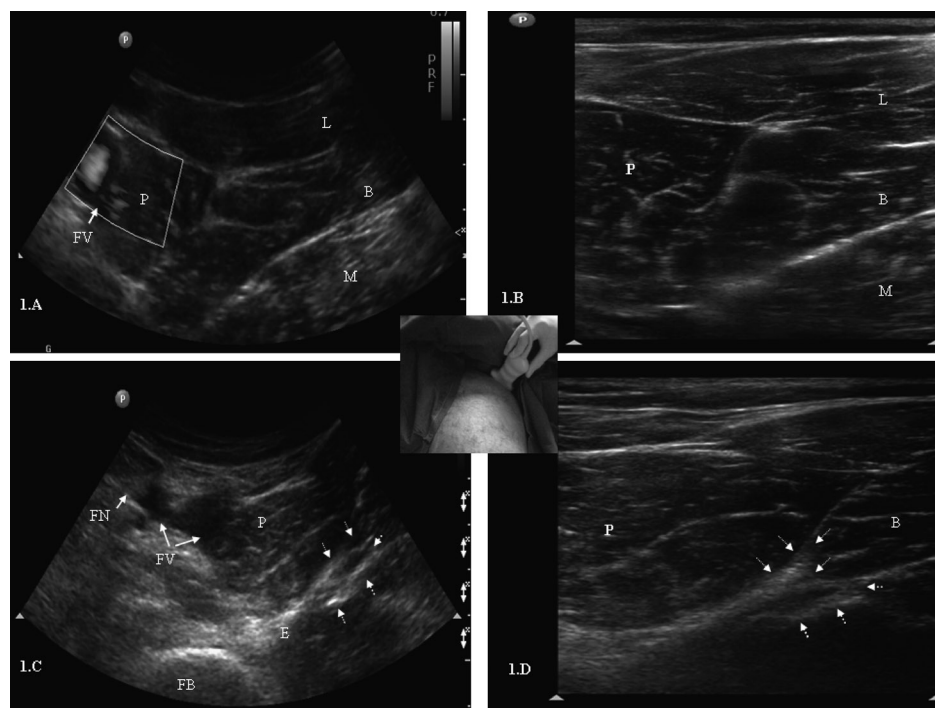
Ultrasound identification of the obturator nerve. (A) The curved 2 to 5 MHz and (B) the linear 5 to 10 MHz transducers were placed perpendicularly just below the inguinal ligament, at the pubic tubercle level. The inguinal region was scanned (inset) and the femoral vessels together with the adductor muscles were also visualized. (C) The curved and (D) linear transducers were then tilted cranially 30° to 40° and a thick hyperechoic fascia (dashed arrows) was visualized, and used as an "imaging" landmark for the identification of the obturator nerve or its divisions. B, adductor brevis muscle; E, obturator externus muscle; FB, femoral bone; FN, femoral nerve (white arrows); FV, femoral vessels (double arrow); L, adductor longus muscle; M, adductor magnus muscle; P, pectineus muscle.
